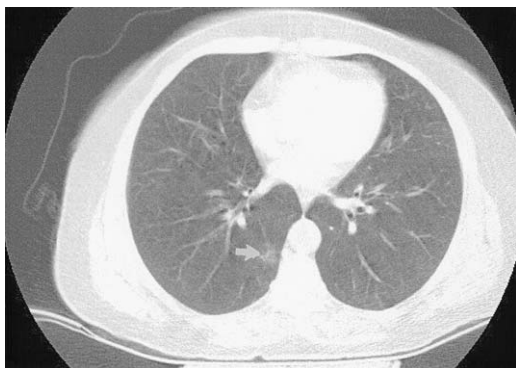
CT of the chest with lung windows shows a slightly irregular ground glass attenuation nodule in the right lower lobe posteromedially (*arrow*). At resection this was shown to be an adenocarcinoma with bronchoalveolar features. This was a stage 1A lesion.
